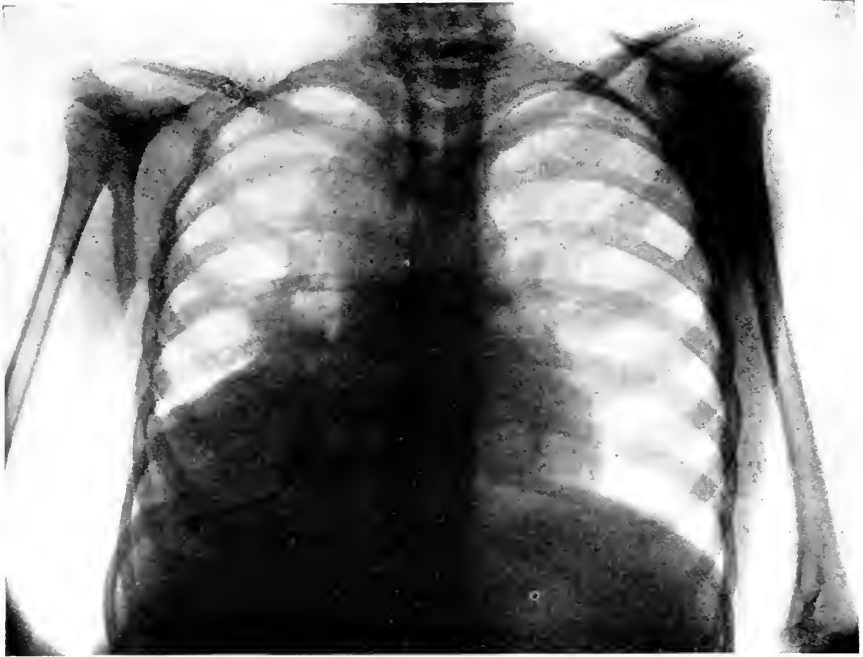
No. 14914 (Phipps Institute). Child age six. Cough, 3 years. Physical signs of a chronic inflammatory condition at right base. Onset of symptoms indefinite. X-ray showed fibrosis of lung and dilated bronchi, due to a bent hatpin measuring  $2\frac{1}{2}$  inches in length with the head down and the point up.
